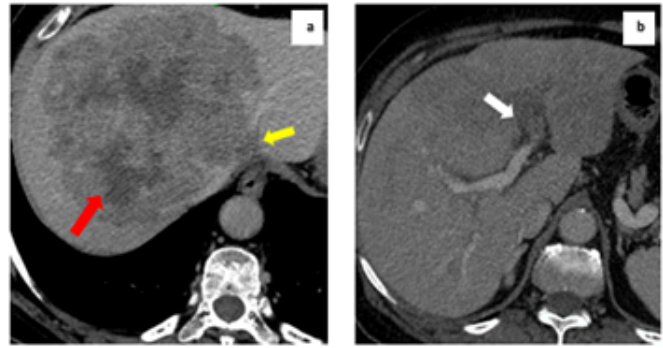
Axial CT portal venous phase image (a) showing a large intrahepatic cholangiocarcinoma (red arrow) with involvement of left hepatic vein near the confluence into IVC (yellow arrow). Also note attenuated calibre of the middle and right hepatic veins. Axial CT portal venous phase image (b) in the same patient shows involvement of the left portal vein and it's branches (white arrow).
